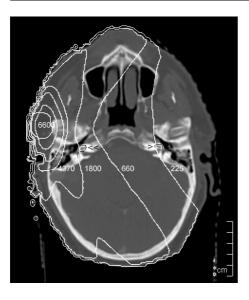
An axial computed tomography scan of a patient treated for parotid gland disease. Intensity-Modulated Radiation Therapy resulted in an isodose distribution indicated with lines 6600 cGy, 4370 cGy, 1800 cGy, 660 cGy, and 225 cGy. The left cochlea (>) and the right cochlea (<<) were delineated to assess the locally applied radiation dose.
